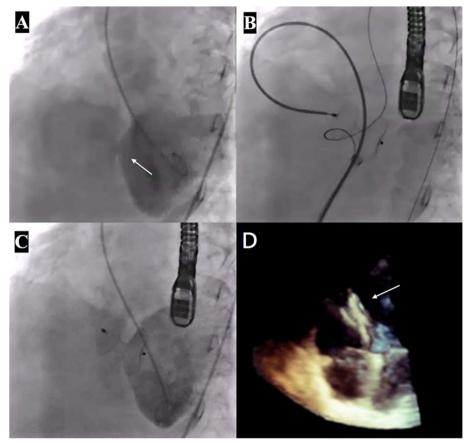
A Left ventriculography showing left to right shunting through a PIVSR (white arrow). B TEE-guided release of an Amplatzer atrial septal occluder device. C Post-release ventriculography showing minimal residual shunt. D Follow-up three-dimensional transthoracic echocardiography after 2 years showing well-seated device on the inter-ventricular septum (white arrow). PIVSR, Post-infarction ventricular septal rupture; TEE, Trans-esophageal echocardiography
